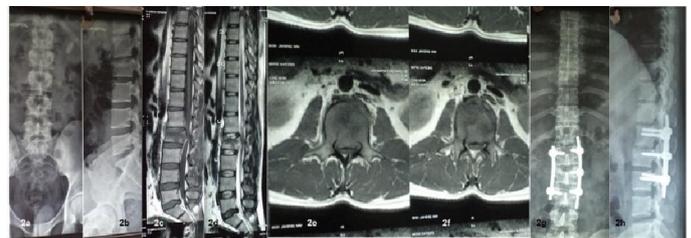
Shows plain X ray AP and lateral view of lumbosacral spine showing Denis type B fracture of L2 vertebral body, MRI shows the retropulsed fragment with kyphotic deformity. Fig 2(g,h) shows follow after 2.5 years with raft screw applied at the fractured vertebra
